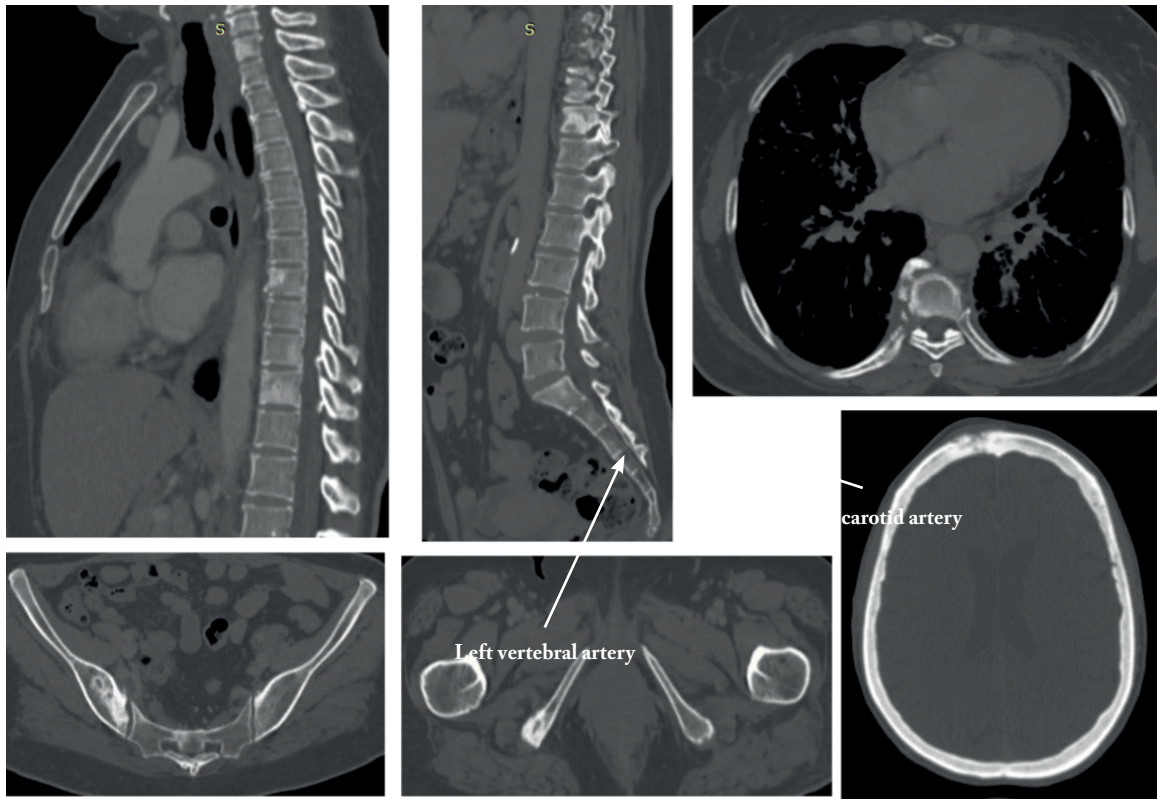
A computed tomography (CT) scan: multiple lytic, sclerotic and mixed bone lesions of C7,D8,D9,D11,S1 vertebra and iliac bone. Aggressive lytic lesion of frontal bone and 6th right rib.
